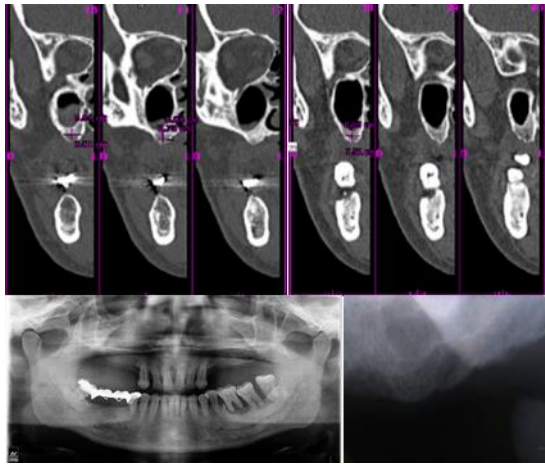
Preoperative CT Scan and OPG And IOPA.
